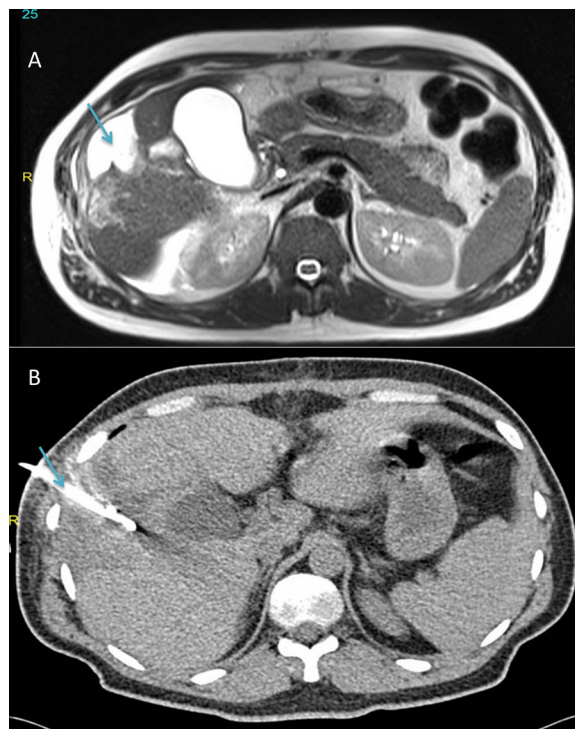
(A) MRCP showing a biloma with no intra or extra hepatic biliary radicles injuries, (B) CT showing drain insertion at the biloma site.
